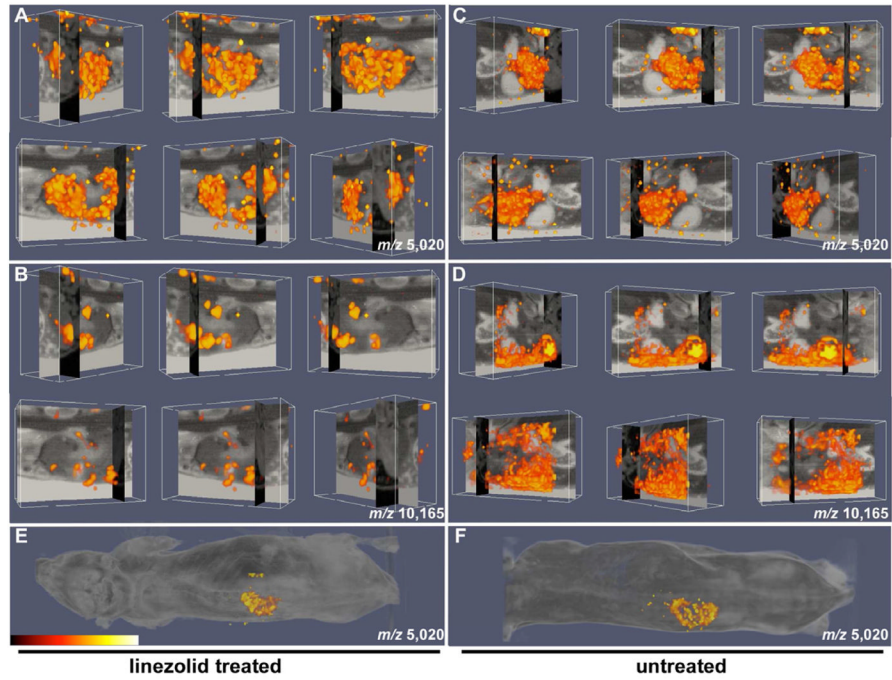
Three-dimensional integration of MALDI IMS and MRI for imaging the inflammatory response to infection
